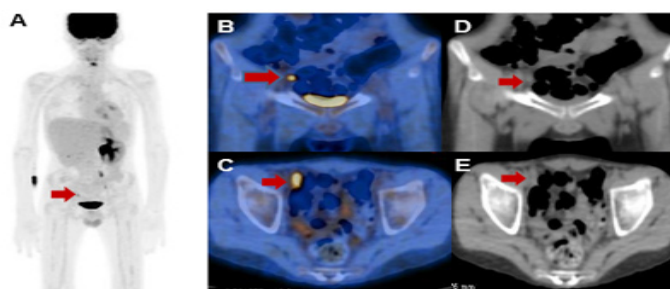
18F-FDG PET/CT scans showing intense focus of FDG uptake at the right base fossa (red arrow) likely related to the tip of the appendix (SUV max 4.5), associated with minimal surrounding fat stranding: A, maximum intensity projection PET; B, coronal fused PET/CT image, C, axial fused PET/CT image, D, coronal CT image, E, axial CT images.
